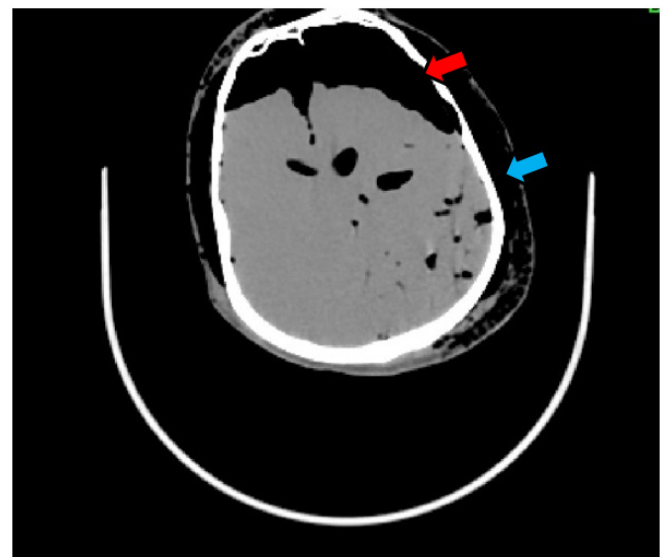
CT brain showing the decomposed gas in cranial cavity (red arrow) & scalp (blue arrow)
